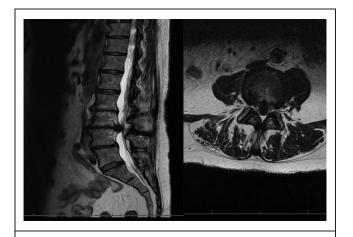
MRI Lumbosacral spine. T2-weighted saggital MR image on the left shows the large L3/4 disc prolapse. T2-weighted axial MR image on the right shows the centrally located L3/4 disc prolapse compressing the cauda equina nerve roots
